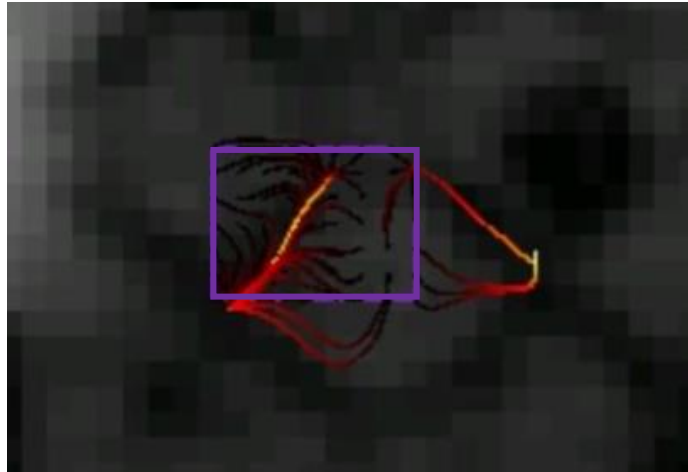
DCE-MRI streamline analysis of single unit geometry slice. The purple box outlines the region involved in the analysis, which is one unit cell of the IsoTruss geometry. Yellow/brighter regions indicate higher velocity; whereas, red/darker regions indicate lower velocity.
